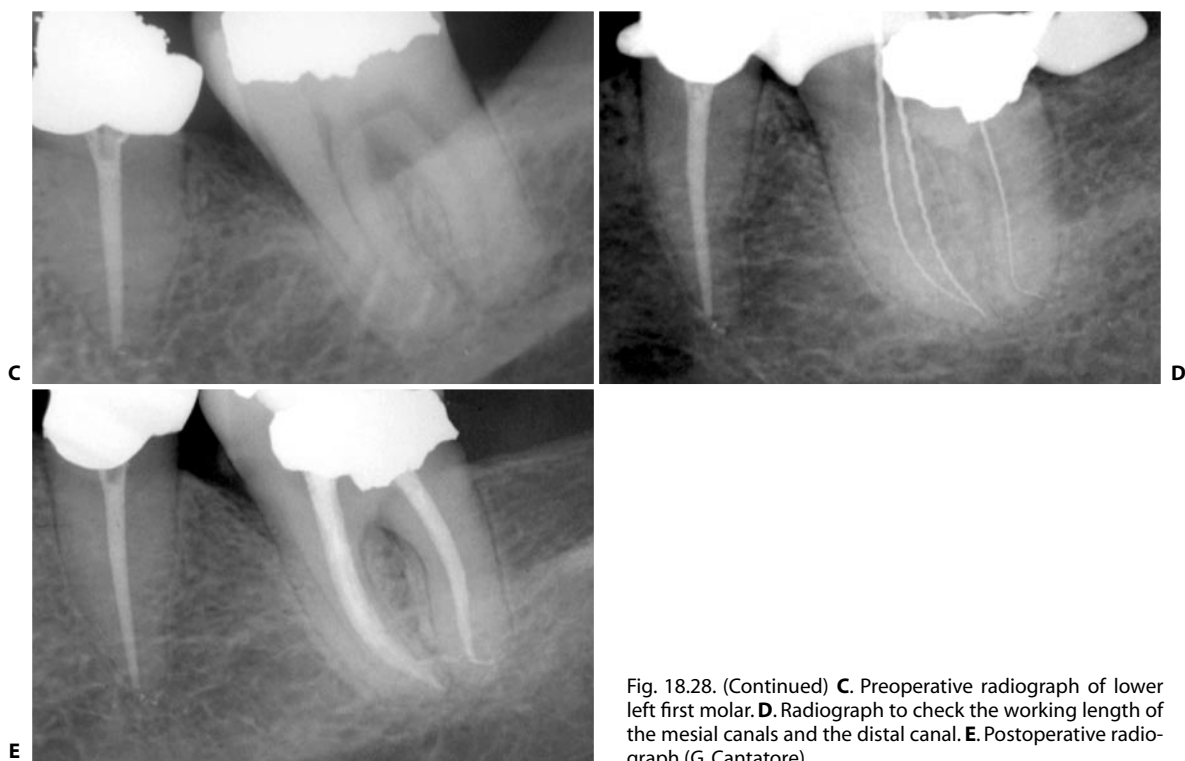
(Continued) C. Preoperative radiograph of lower left first molar. D. Radiograph to check the working length of the mesial canals and the distal canal. E. Postoperative radiograph (G. Cantatore).
